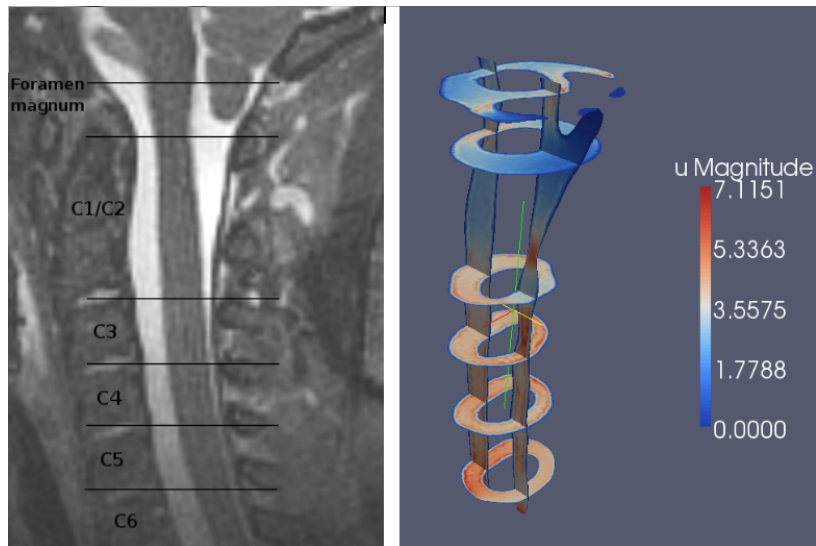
Axial levels at which we choose to extract the data (left). The velocities at the extracted levels visualized in Paraview (right). It should be noted that the MR image to the left is not of the modelled patient to the right.
